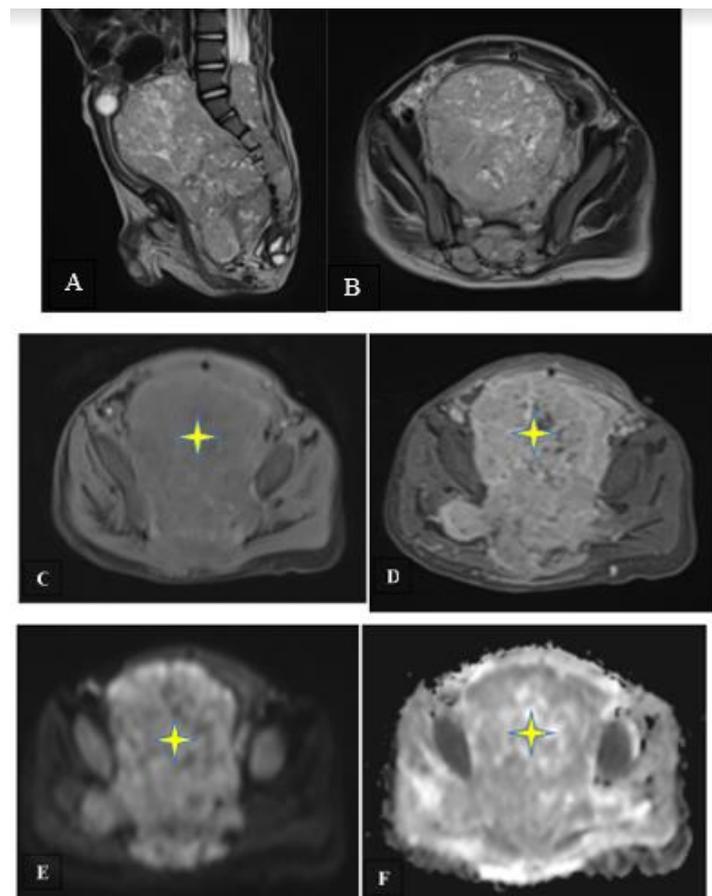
Pelvic MR imaging of the mass showing a centropelvic tumoral process (stars), with involvement of the sacrococcygeal region, on sagittal (A) and axial (B) T2 weighted fast spin echo, T1W fat suppressed axial image pre-contrast (C) and post-contrast (D), Diffusion-weighted sequences (E, F). The masse is demonstrating a heterogeneous high signal T2 (A, B), with cystic areas, intermediate T1 signal intensity (C), discrete high signal diffusion with ADC restriction (E, F) and heterogeneous post-contrast enhancement (D). This mass is causing mass effect on the catheterized bladder (white arrows) and an extensive sacrococcygeal endocanal invasion extending to the lumbar medullary canal (red arrows)
